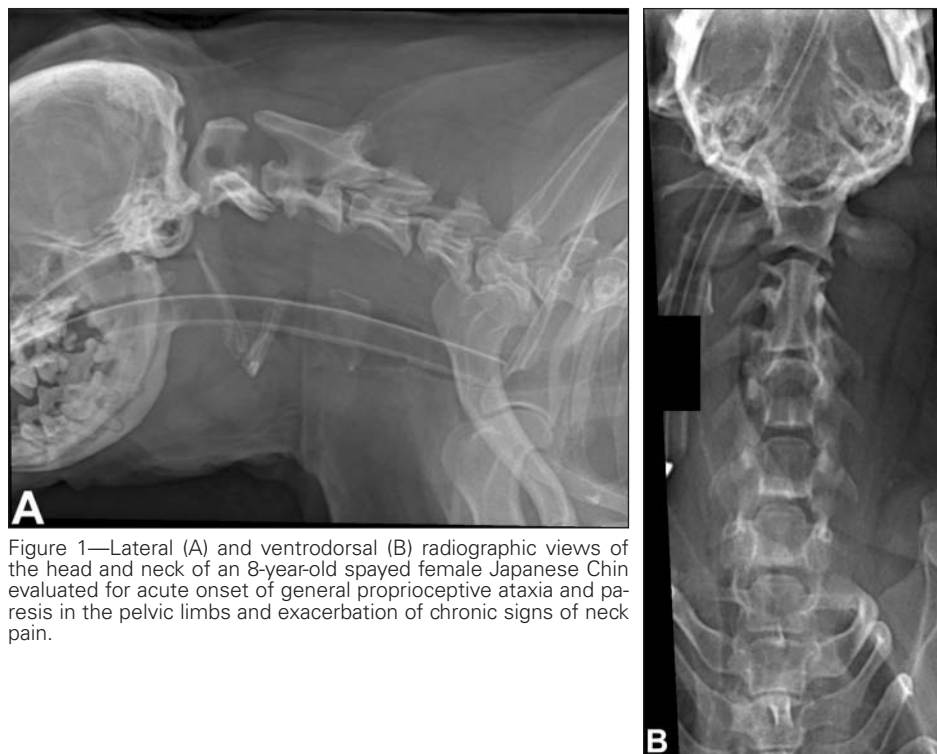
Lateral (A) and ventrodorsal (B) radiographic views of the head and neck of an 8-year-old spayed female Japanese Chin evaluated for acute onset of general proprioceptive ataxia and paresis in the pelvic limbs and exacerbation of chronic signs of neck pain.
